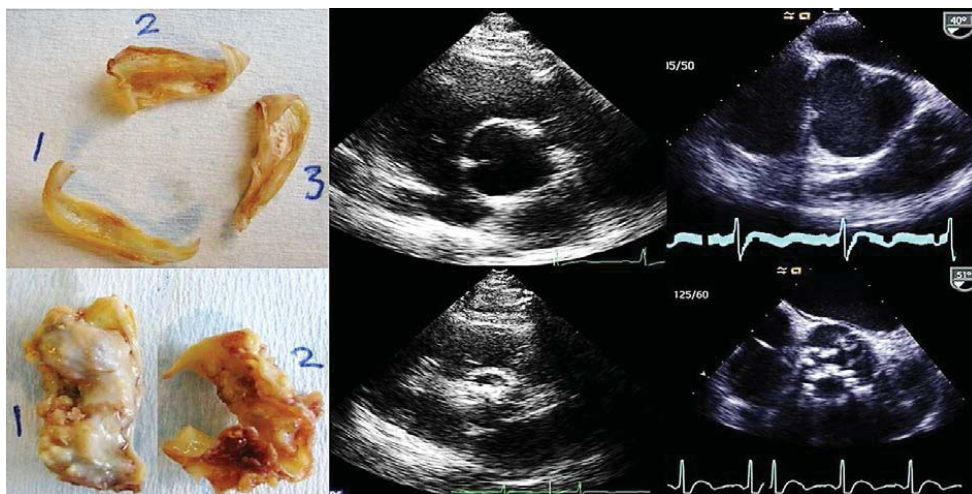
Sample valves from the study showing explanted valves, transthoracic and transoesophageal echocardiographic images (left to right). Top, mildly thickened tricuspid aortic valve. Bottom, heavily calcified bicuspid aortic valve.
